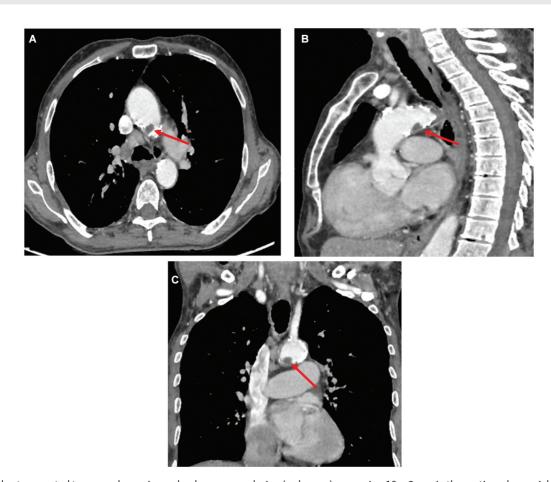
A chest computed tomography angiography shows a mass lesion (red arrow) measuring 10 × 9 mm in the aortic arch on axial section (A), sagittal section (B), and coronal section (C).
